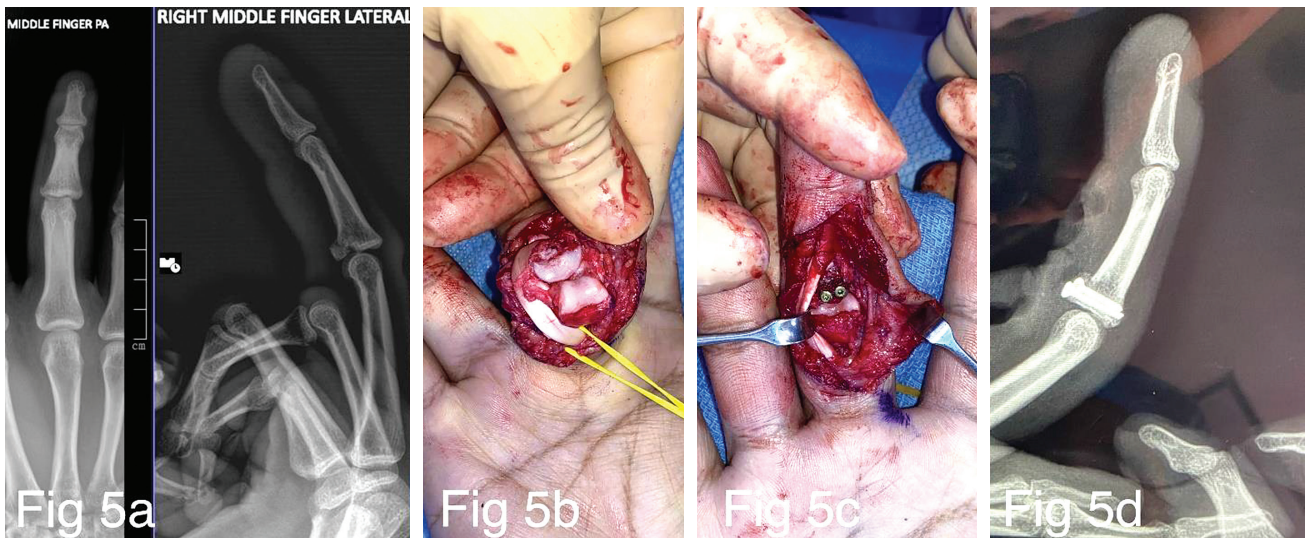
The injury film shows a PIPJ-DFD of the middle finger with approximately 40% volar lip involvement (A). The “shotgun” image of the PIPJ (B). The PIPJ was reduced, and the graft fixation was stable with two 1.5 mm screws (C). Radiograph showing a concentric reduction of the PIPJ and stable fixation (D).
